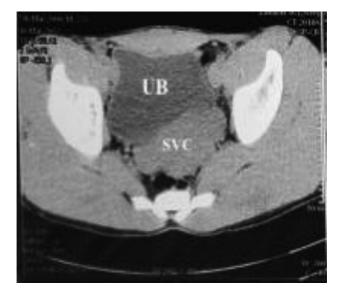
CT scan image (axial cut) showing urinary bladder (UB) and seminal vesicle cyst (SVC).
